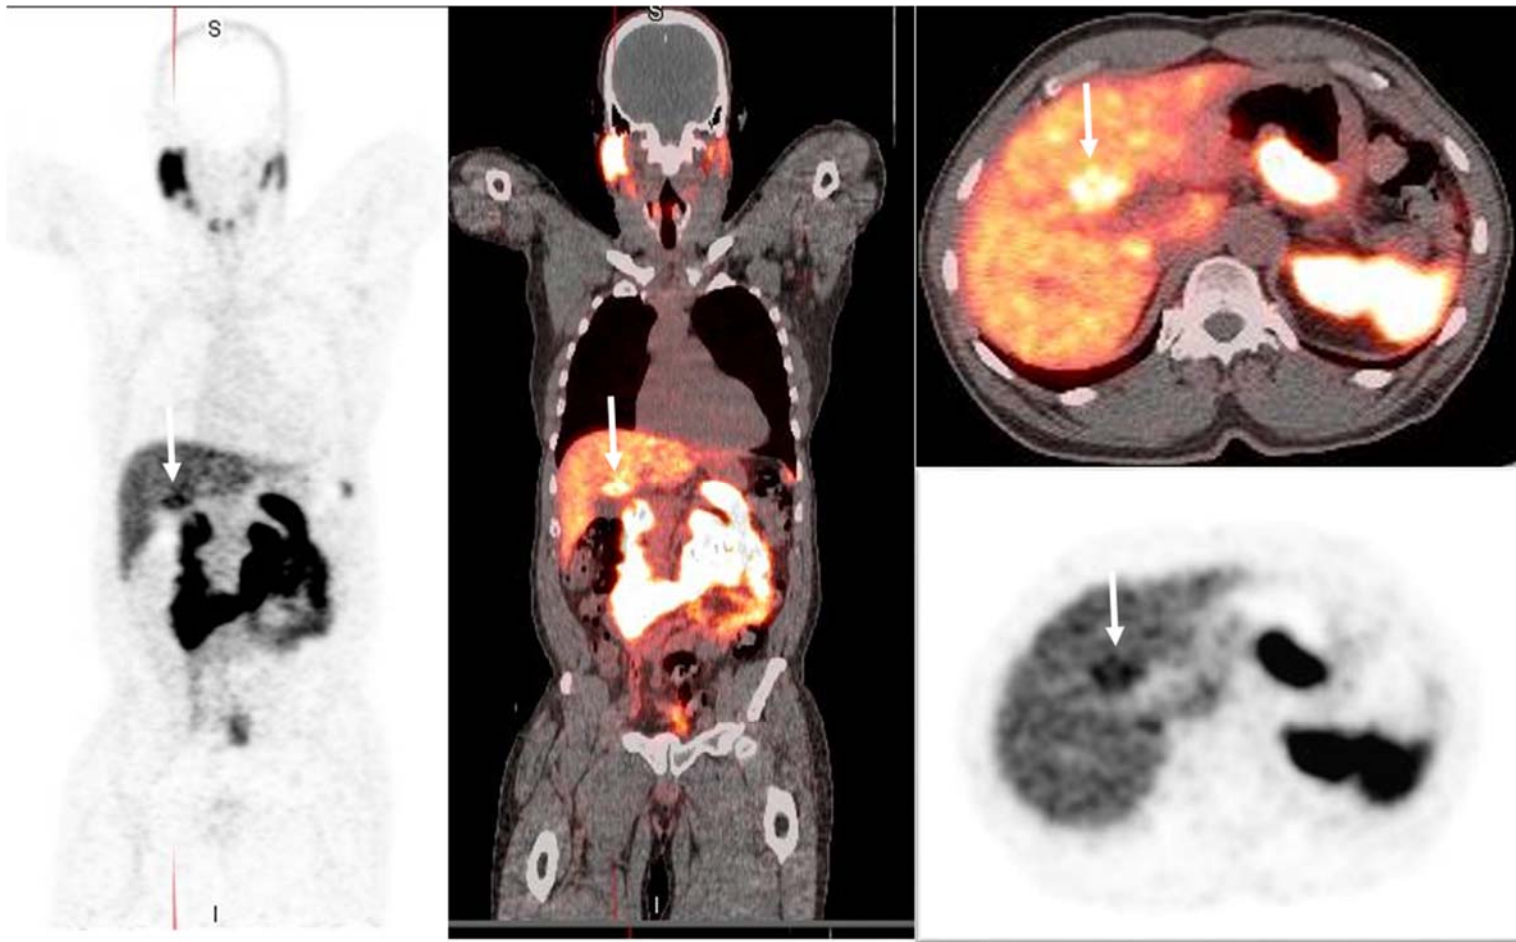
Case 3: A 71-year-old man with a history of PCa (Gleason 3+4) and radical prostatectomy. ^{68}Ga -PSMA PET/CT was obtained and localized PCa recurrence in a left obturator node (not shown) at a PSA of 3.98 ng/mL. An intense area of radiotracer avidity is seen in hepatic segment IVb, similar to the two cases above. No abnormality was seen in hepatic segment IVb on subsequent ceCT. Abdomino-pelvic MRI (not shown) four weeks prior to this PET/CT also did not demonstrate any hepatic lesion. No aberrant vessel could be identified though the study was not optimized for this indication.
